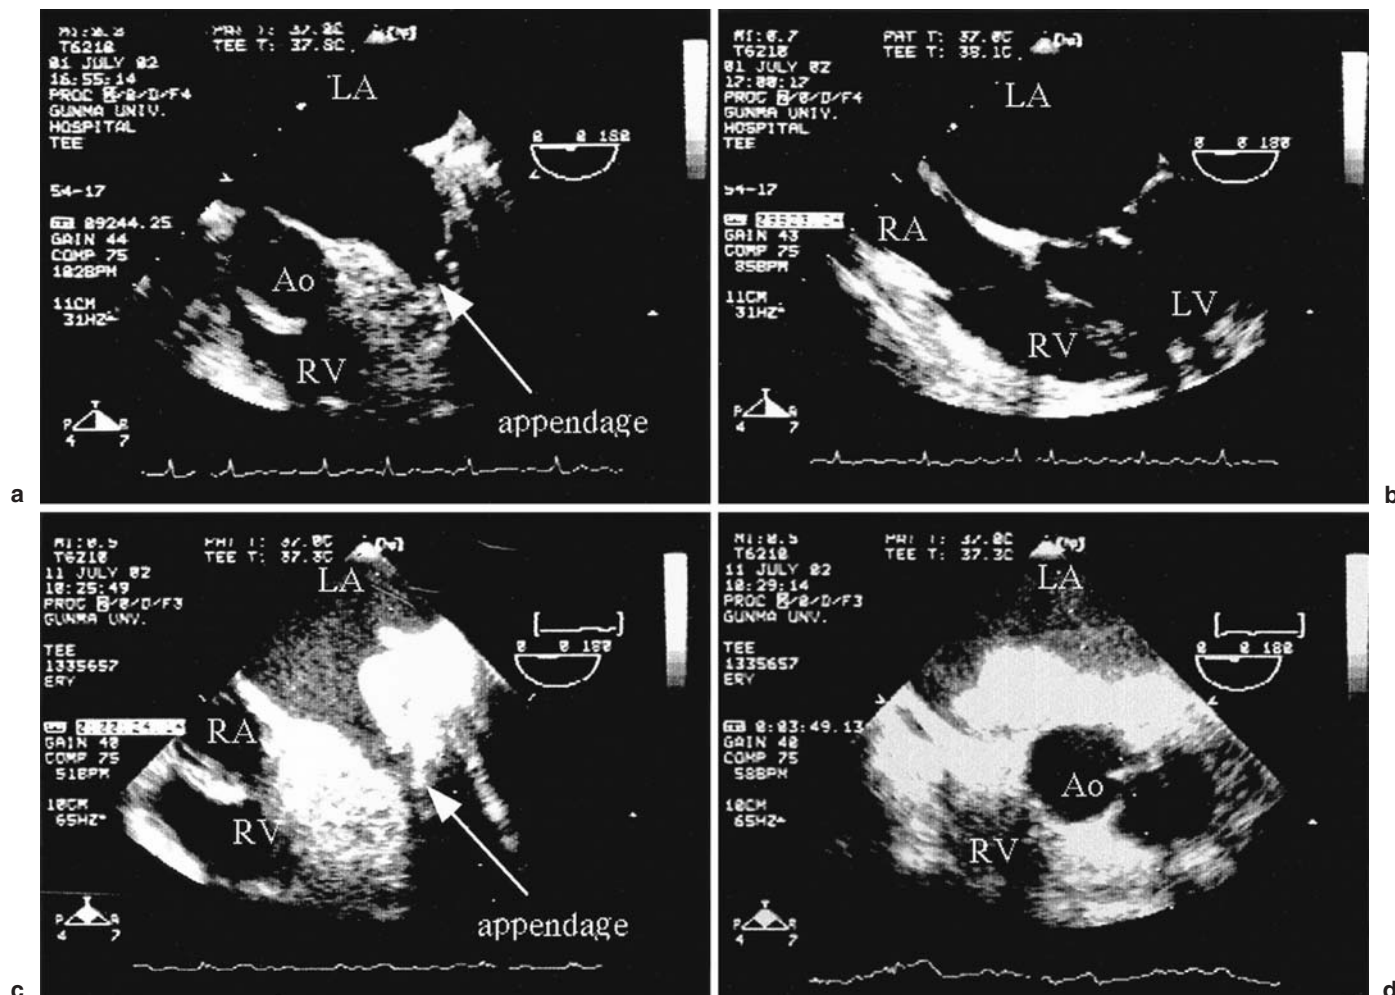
a,b Images from transesophageal echocardiography during the preoperative period. There was no thrombus formation in the left atrial appendage (a) and the left atrium (b). c,d Images from transesophageal echocardiography during
